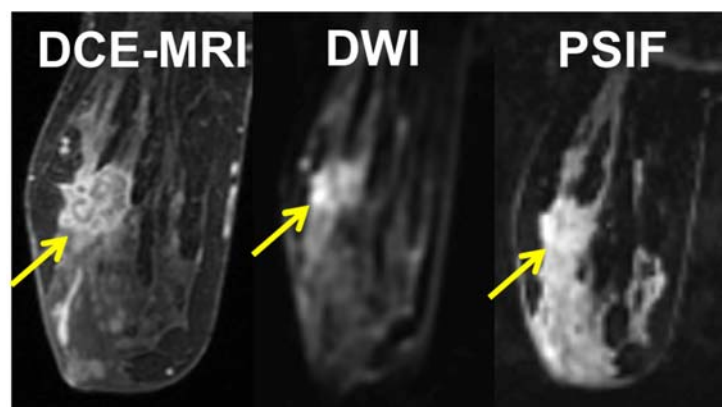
High-grade triple negative breast cancer (yellow arrows). PSIF demonstrates reduced distortion and improved resolution of irregular tumor borders, but lower contrast and less suppression of normal fibroglandular tissue in comparison to EPI-DWI.
